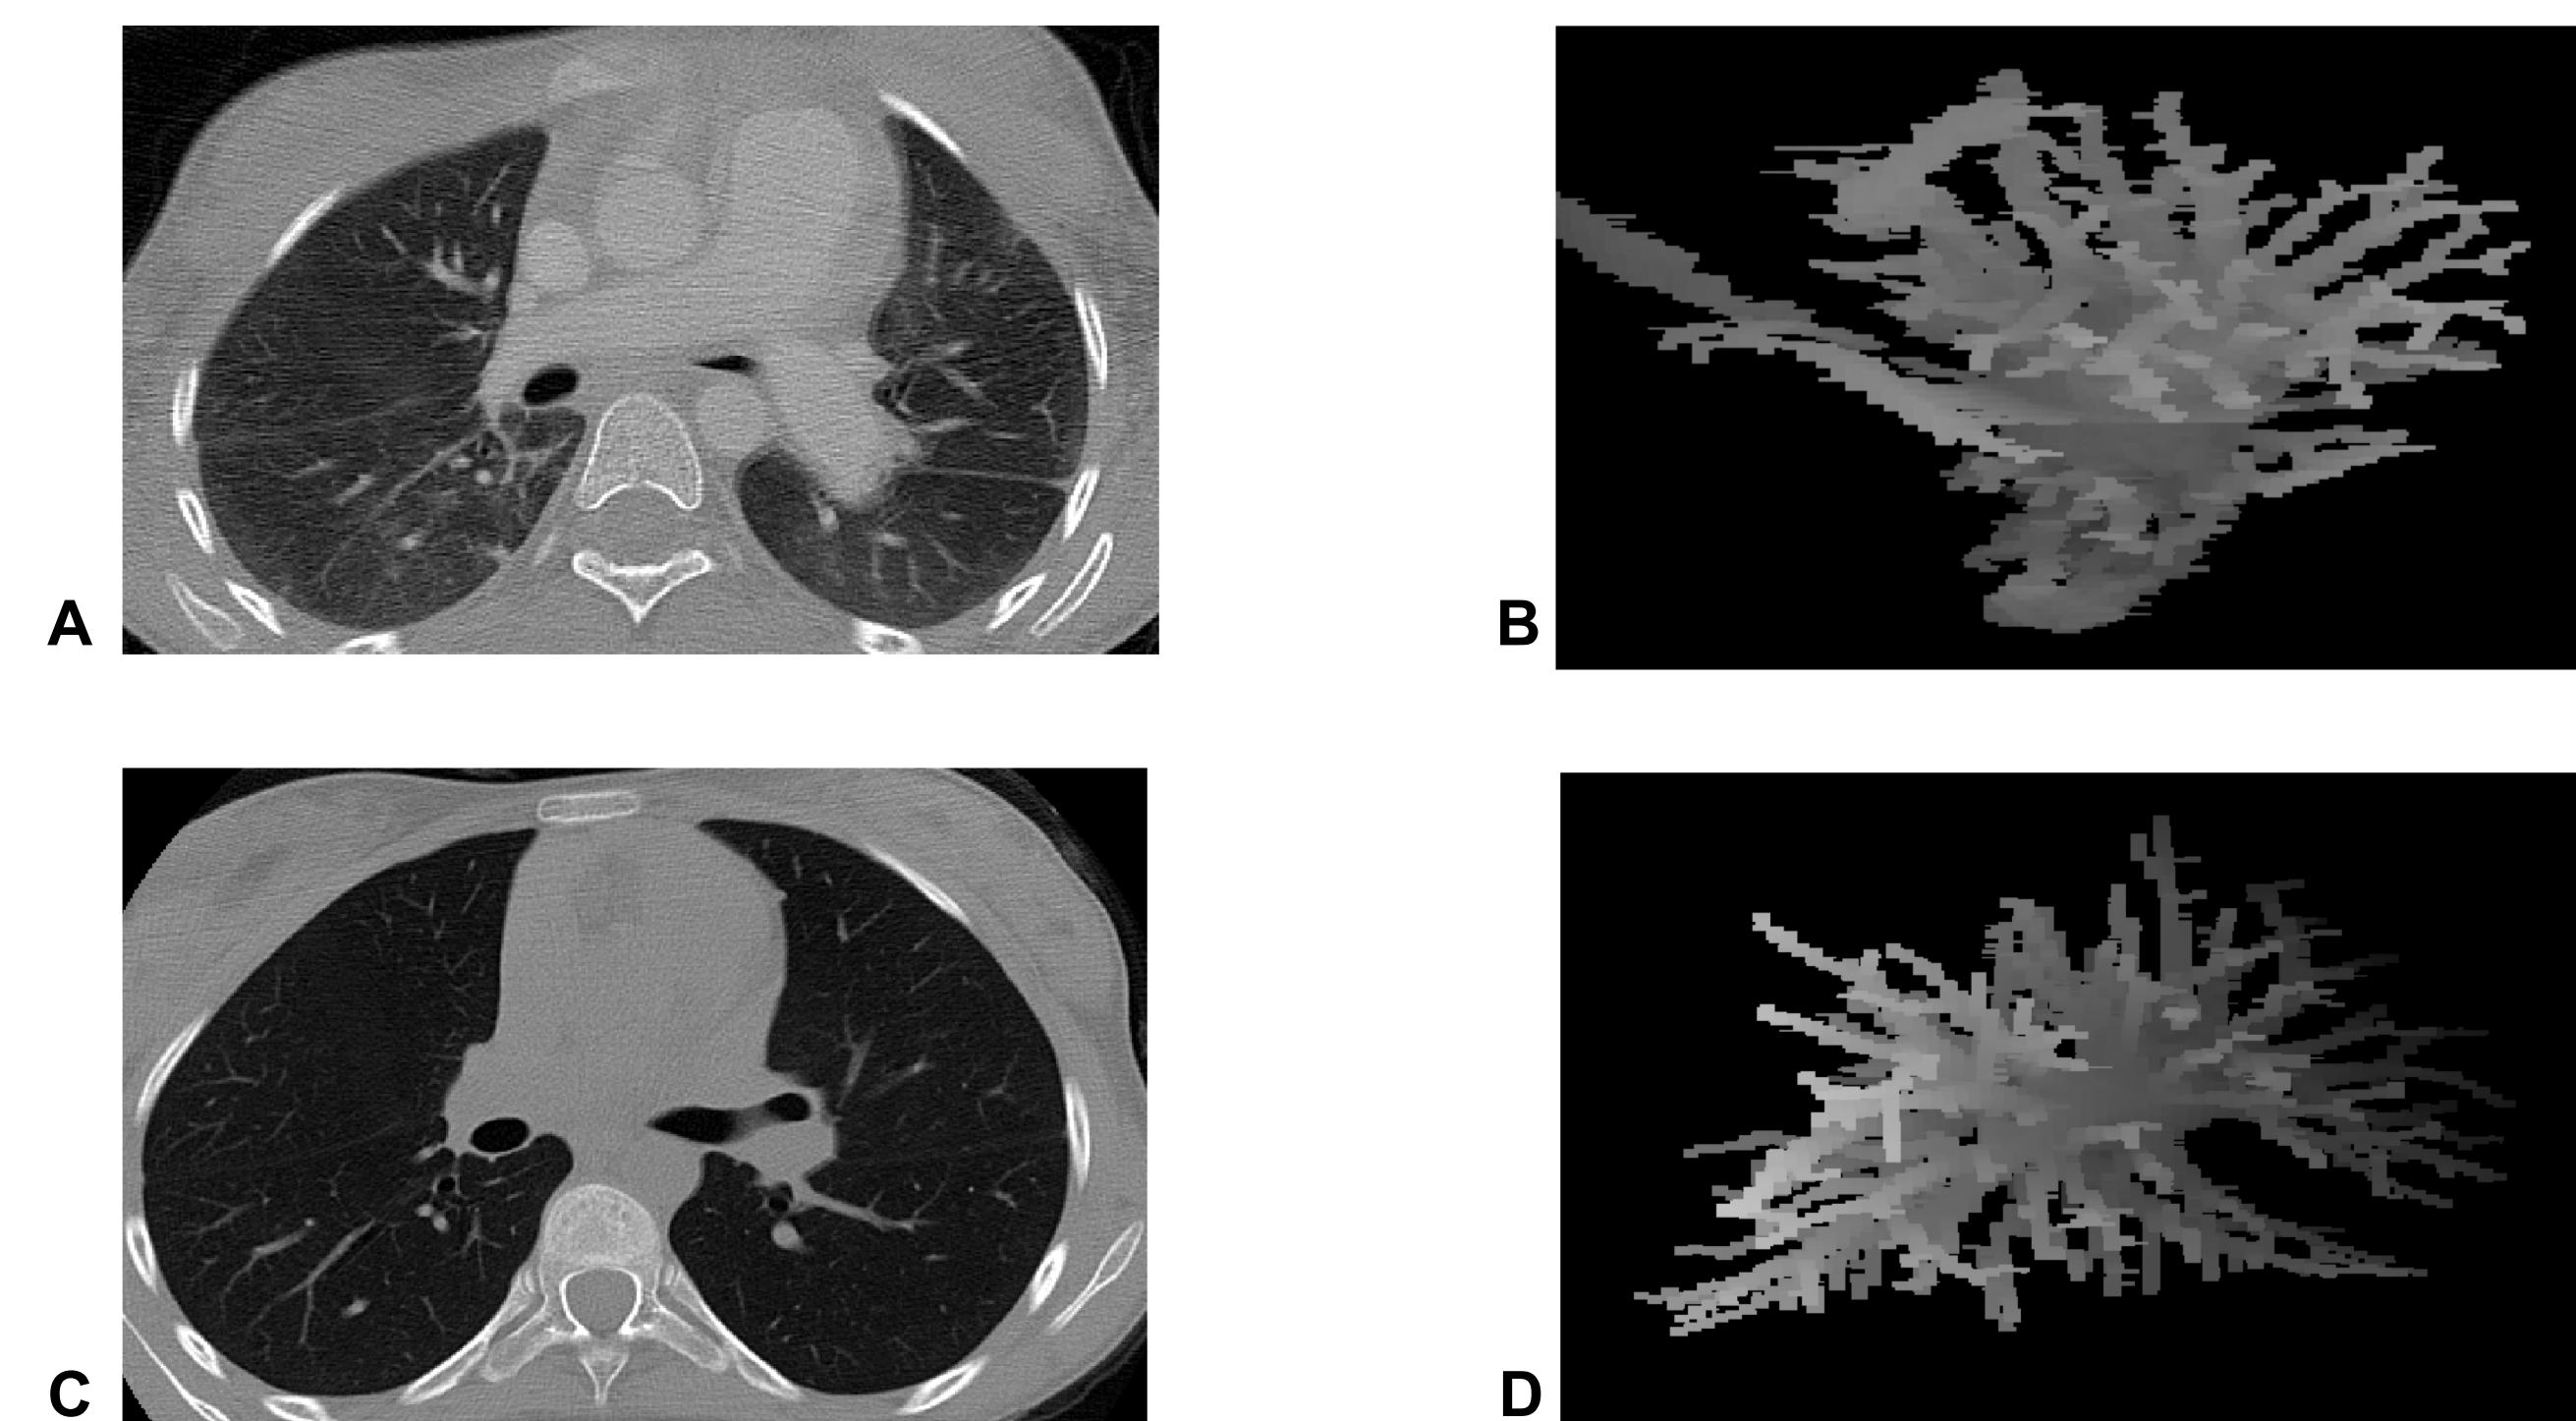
Visual inspection of vessel tree extraction results. Images [A] & [C] each show a single slice of a chest CT scan for a patient acquired at 13 and at 14 years of age, respectively. [B] and [D] show the extracted vessel trees for the same time points. The number of branches slightly increased over time (data plotted in Fig. 4A), however, the resolution of these lung scan were lower than ideal (3 mm slice thickness) which reduces our ability to account for vessels < 3 mm in diameter.
